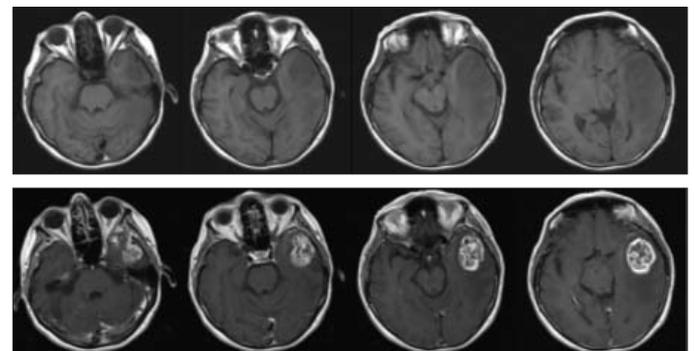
March 2010 MRI; Axial unenhanced T 1-weighted images showing hypointense (A) and axial contrast enhanced T 1-weighted images showing mass lesion with contrast enhancement (B) in the left temporal lobe corresponds to hypermetabolic lesion in FDG-PET imaging. Oedematous changes are also seen around the mass lesion
